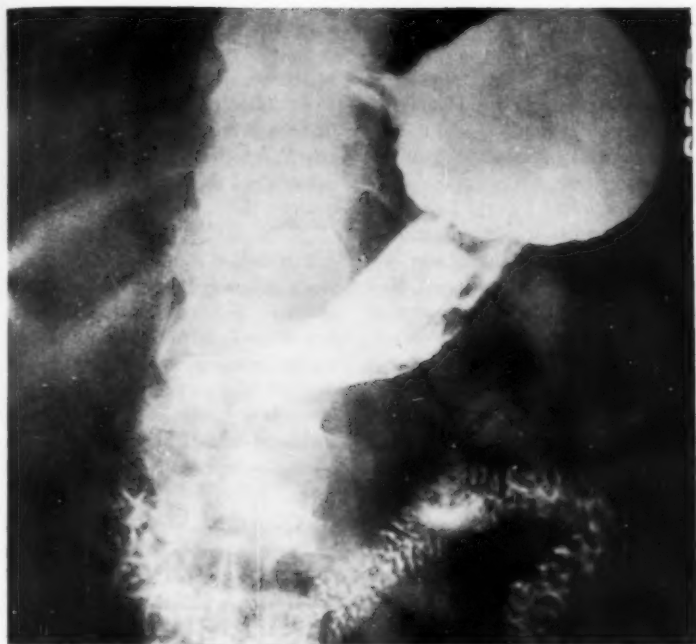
In multiple x-ray exposures of the stomach, there is a consistent subtractive defect along the greater curvature in a polypoid configuration.
